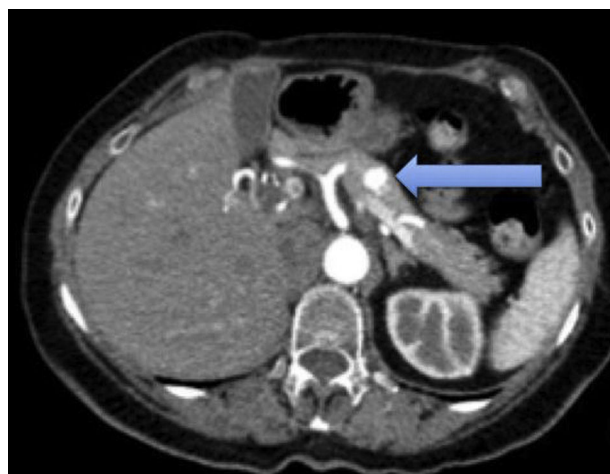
Axial slice of computed tomography of the abdomen without intravenous contrast in arterial phase. A hypervascular lesion of 11 mm diameter is observed in the body of the pancreas, which quickly presents contrast lavage.
